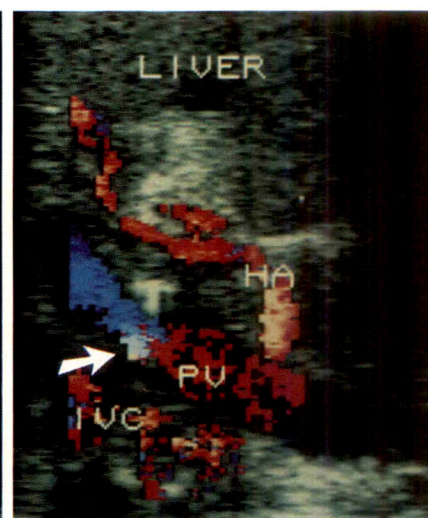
Reversed flow of portal vein. Right coronal oblique sonogram of hepatic hilum. Central streamline systolic flow is in a prominent hepatic artery (HA) and intrahepatic arterial branches. Main and intrahepatic portal vein branches are color-encoded blue, indicating flow reversal. Part of extrahepatic portal vein is obscured by a rib shadow. PV = portal vein. (Reprinted with permission from Foley [2].)
